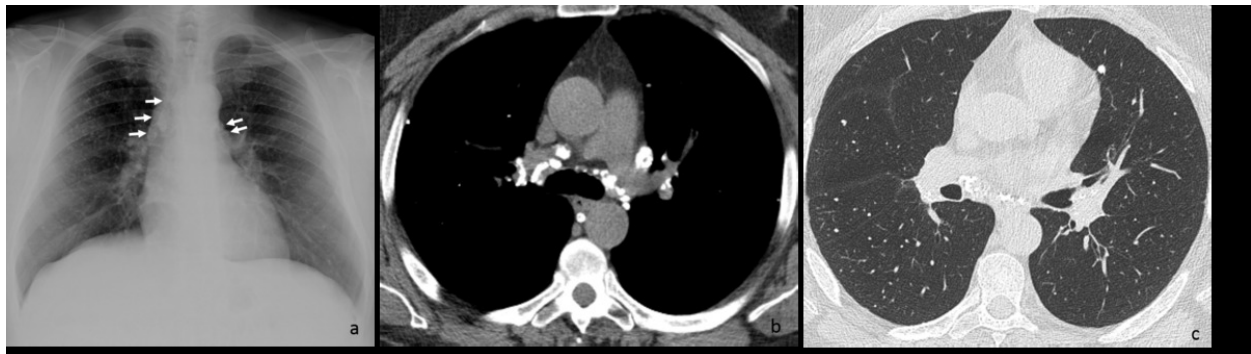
The plain radiograph (a) demonstrates the presence of bilateral, regular-contour hilar nodes with peripheral calcifications (white arrows). In the lung parenchyma, multiple peripheral micronodes predominating in the upper and middle zones of the thorax are seen. The CT of the same patient reveals the presence of multiple hilar lymph nodes with egg-shell calcifications (b). On the lung window (c), multiple peripheral calcified micronodes are seen.
